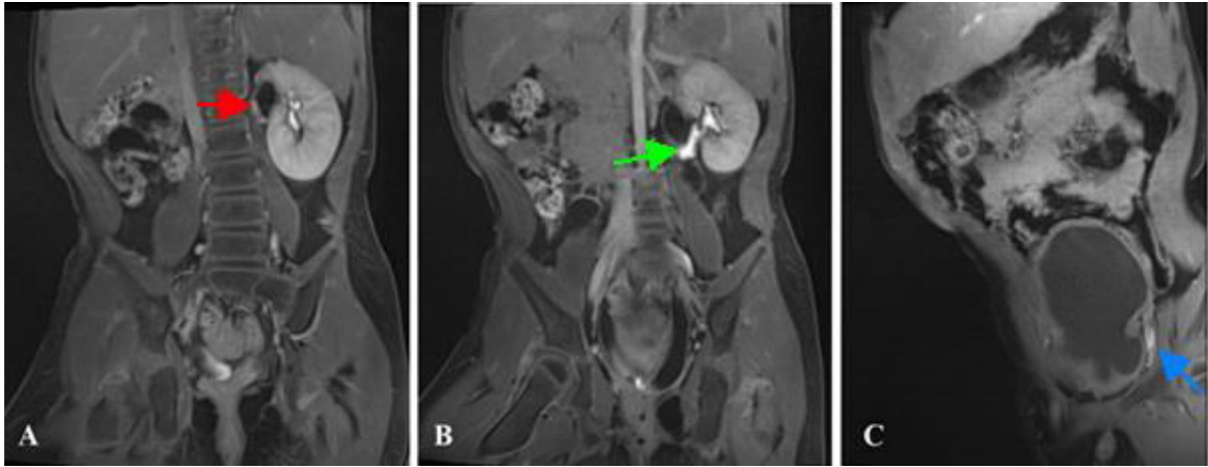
Delayed phase of contrast-enhanced T1-weighted image with fat saturation. (A) and (B) Coronal image showed the nonfunctional upper pole ureter (red arrow) and functional middle pole ureter (green arrow). (C) The functional left ureter (blue arrow) entered the bladder at the bladder trigone.
